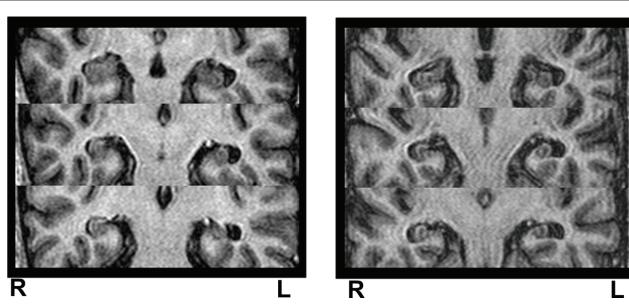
Example of MRI acquired at time zero (MRI 1) and after 20 months (MRI 2), in a patient with FMTLE. Hippocampal volumetry demonstrated left hippocampal atrophy at MRI 1 (left Z-score = -2.33) and bilateral hippocampal atrophy at MRI 2 (left Z-score = -3.63 and right Z-score = -2.81), indicating progression of left hippocampal atrophy and the development of right hippocampal atrophy overtime. R, right side; L, left side.
